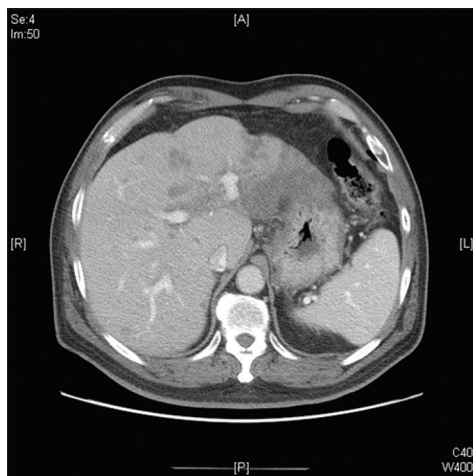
Follow-up computed tomography scan revealed regression of right liver tumors on November 18, 2020
